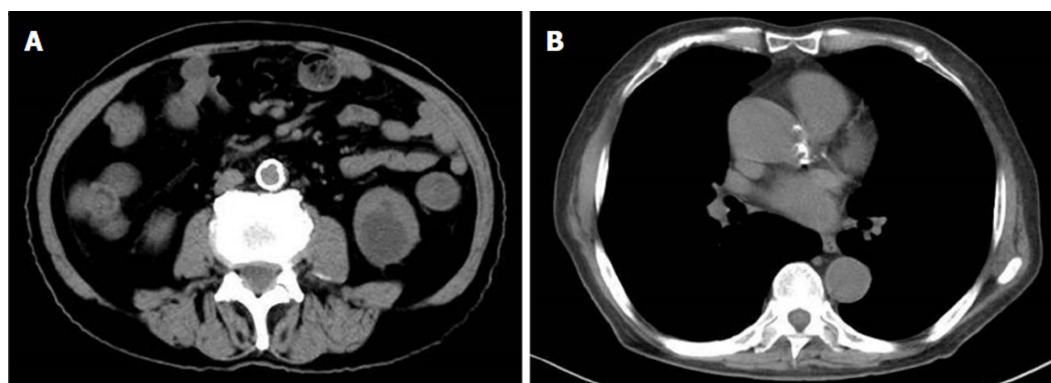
Pre-surgery computed tomography examination. A: A soft tissue shadow of the ileocecal junction and adjacent ileum surrounded by multiple swollen lymph nodes; B: Aortic and coronary atherosclerosis.
